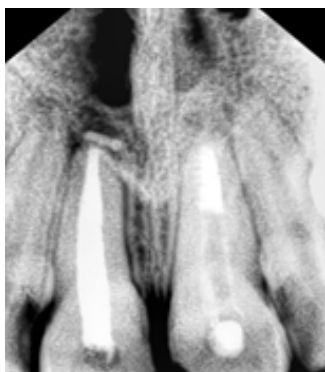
2 months follow up radiograph
